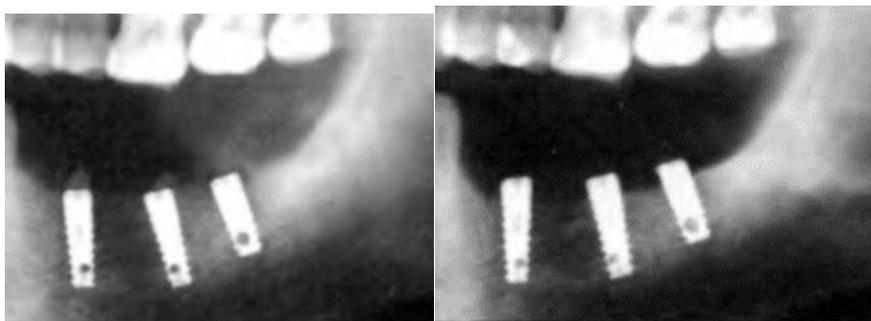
No. 1 X-ray of patient M., 45 years old. in the area of implants in the absence of functional load
